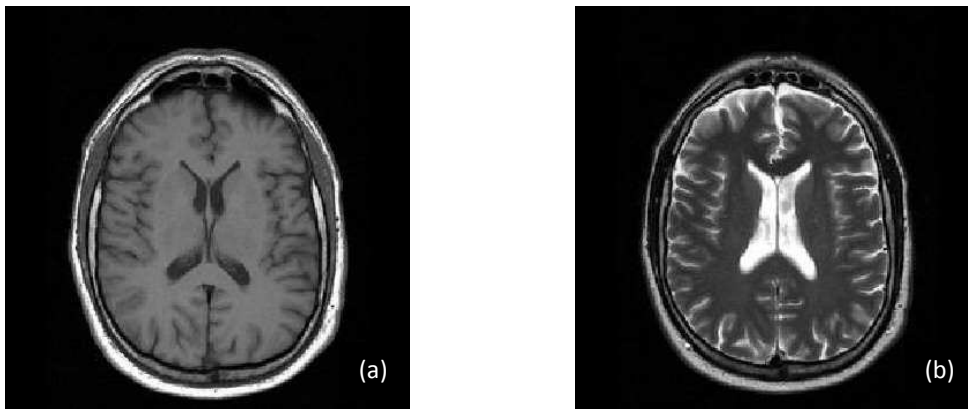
(a) T1-weighted image of the brain, showing cerebrospinal fluid in dark, brain matter in mid-gray and adipose (fat) tissue in bright tones; (b) T2-weighted image of the brain showing cerebrospinal fluid as very bright and brain and other types of tissue in mid-gray. From www.mr-tip.com.
